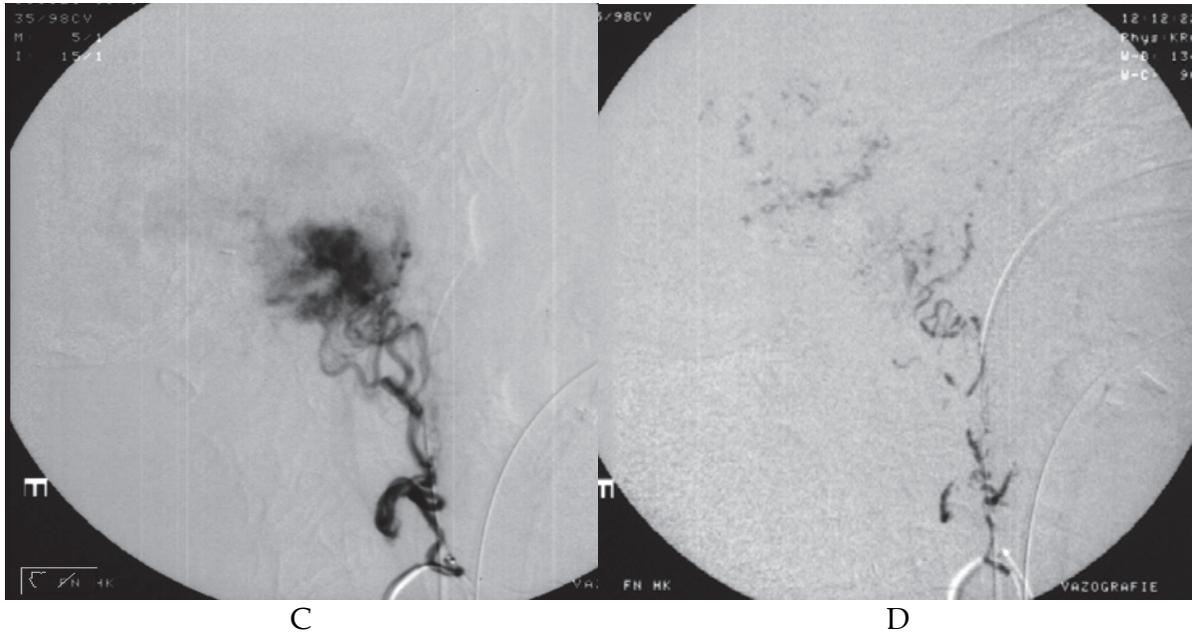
A 48-year-old woman with large paraganglioma. A. The left common carotid angiogram reveals ligation of the external carotid artery which was done during previous surgery. B. The late arterial phase shows opacification of hypervascularized tumor. C. The external carotid was reached via collateral branch from the superior thyreoidal artery. D. The subtracted image demonstrates injection and penetration of the acrylic glue into the vascular bed of the tumor. E-G. Follow-up contrast enhanced CT scans revealed central necrosis with radiopaque glue deposit inside it.
